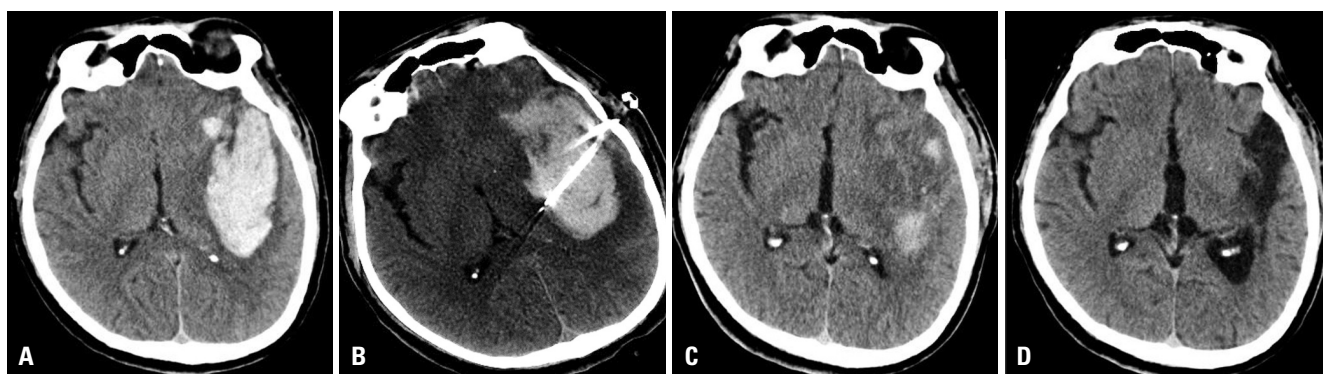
On a computed tomography scan, (A) a lobar-type subcortical hemorrhage is noted on the left temporal lobe. (B) We performed catheterization for hematoma drainage. (C) Fourteen days later, the hemorrhage was well resolved. (D) On 12-month follow-up, encephalomalacic change (tissue defect) was detected on the left temporal lobe without any other abnormal lesions.
